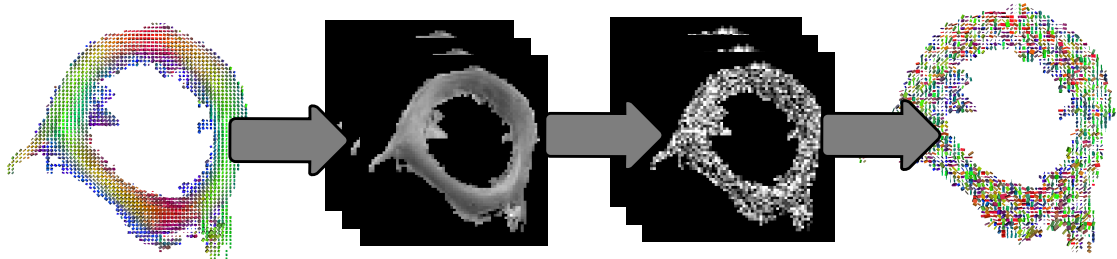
Ex-vivo* experiment: 6 Diffusion Weighted Images (DWIs) were artificially computed from the reference tensor field. Each DWI was corrupted by additive Rician noise, and the tensor field was then estimated. The variance of the added Rician noise in this example was $V = 0.04$ for each DWI, which results in a signal to noise ratio of 10.0.
